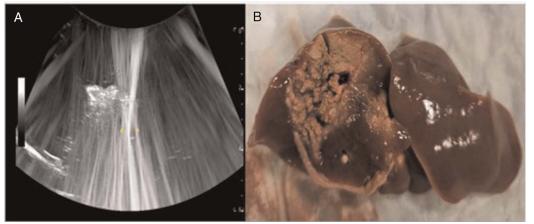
In vitro chicken liver results. (*A*) Diagnostic ultrasound image during HIFU ablation with focus targeted approximately 1 cm below the liver surface. (*B*) Cross-sectional slices of ex vivo liver with total ablation time of 100 seconds (five 20-second burst moved linearly across the liver edge).
